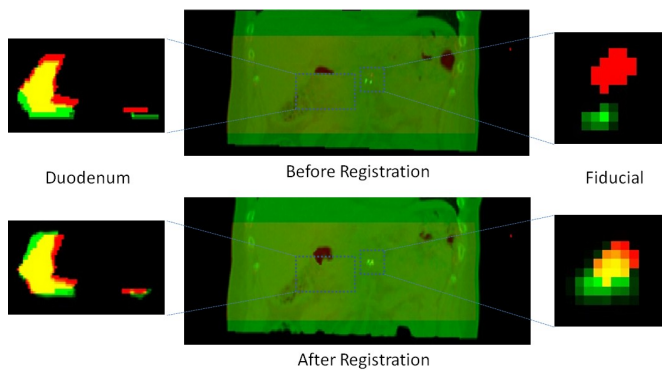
Top left: Image overlay of a coronal slice of the duodenum segmentation before registration. Segmentation from the reference CT is in green and from reconstructed CBCT in red. Yellow is the overlapping region. Bottom left: Green denotes the duodenum segmentation deformed by the estimated deformation parameters. Top center: Image overlays of the reference CT (green) and the reconstructed CBCT (red). Bottom center: Images overlays of the estimated CT (green) and the reconstructed CBCT (red). Top and bottom right: Coronal image overlays of the fiducial marker segmentation.
